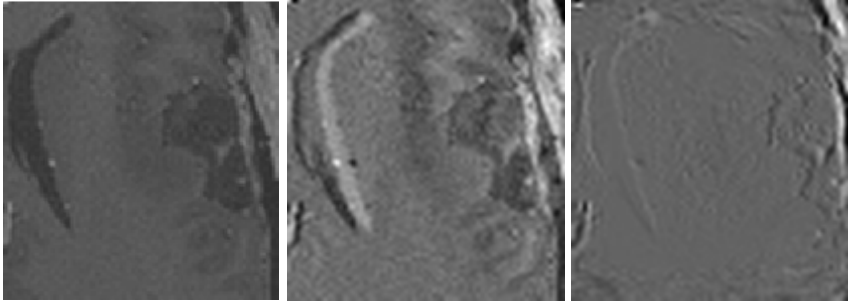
Left: A transverse slice through the ROI in the original MR image. Middle: Difference image between the original and the transformed image before registration for a displacement of -10 mm. Right: Difference image between the transformed and the deformed original image after registration.
